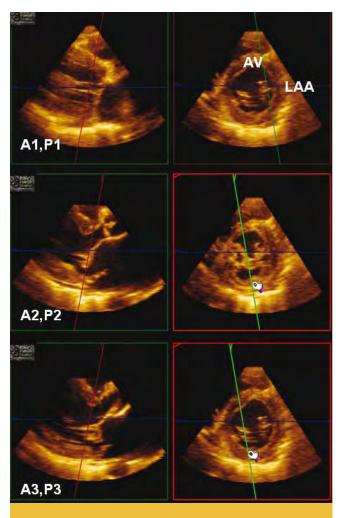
Segmental analysis of the mitral valve: Transthoracic full-volume 3-D dataset taken from the parasternal long axis window. Using multiplanar reconstruction format long axis and short axis views are displayed at three levels. The level of each segment is confirmed in short axis and then assessed during systole in long axis. The images shows P2 flail segment with additional prolapse of P3 and A3.
